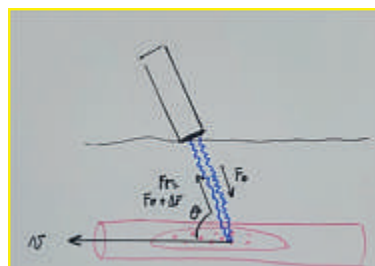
The Doppler effect.
